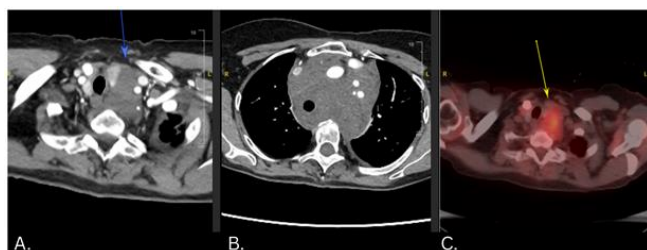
PET/CT Findings.
